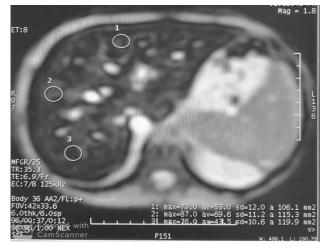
A 10 years old female child diagnosed with thalassemia major disease. Clinically, the patient showed anemia and hepatosplenomegaly when receiving regular transfusions of blood every 23–25 days. A laboratory analysis found that the blood ferritin level was up to 1270 ng/ml [normal range: 21.8-247.6], and the albumin level was normal at 3.6 [normal range: 3.4-5.4] and the bilirubin level was elevated to 1.7 [normal range: 0.1-1.2]. Specifically, higher ALT 51 [normal range: 10-44] and AST 44 [normal range: 10-34]. A liver MRI [T2*] revealed a low T2* of 3.09 ms, indicating a moderate hepatic iron excess [LIC 9.5mg/g].
